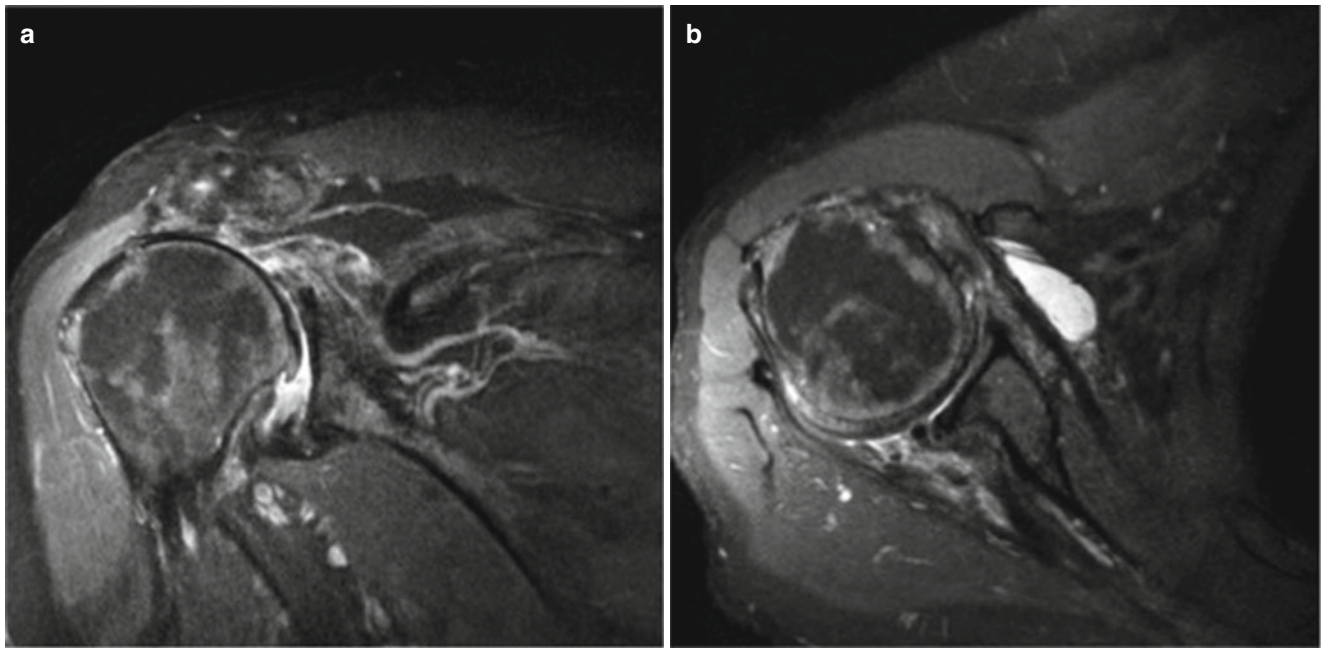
MRI of a right shoulder of 77 male patients with Hamada 3 cuff tear arthropathy. (a) Coronal T2 fat suppressed FSE. Acromio-humerus distance <5 mm with acetabularization of acromion. (b) Axial PD fat
